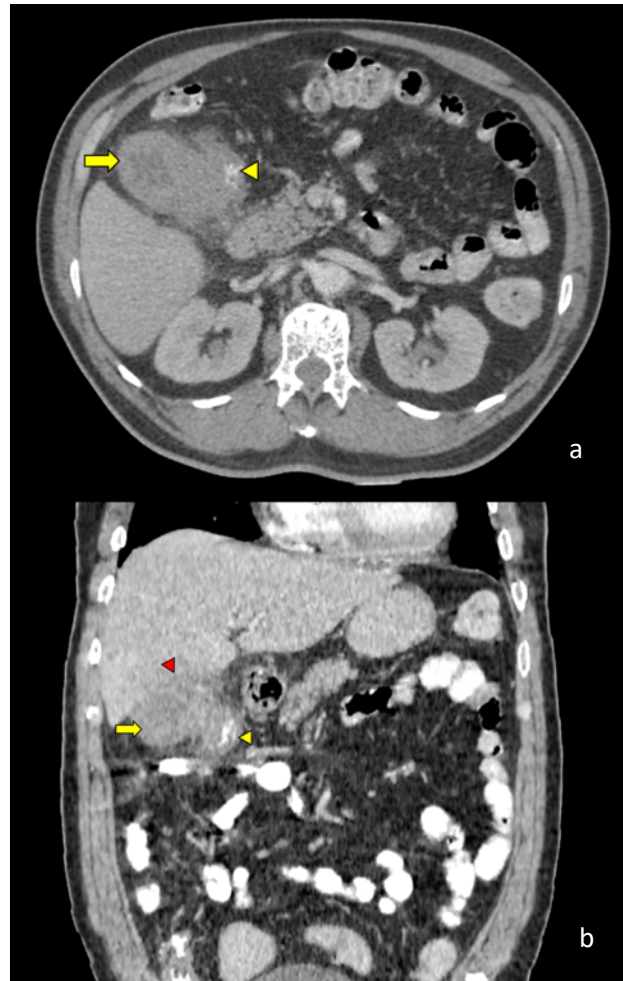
Axial (a) and coronal (b) CT images of the abdomen demonstrating an ill-defined mass at the hepatic flexure (yellow arrowhead) intimately related to the gallbladder with markedly irregularly thickened walls (yellow arrow), with loss of delineation of the gallbladder from the liver bed (red arrowhead).
